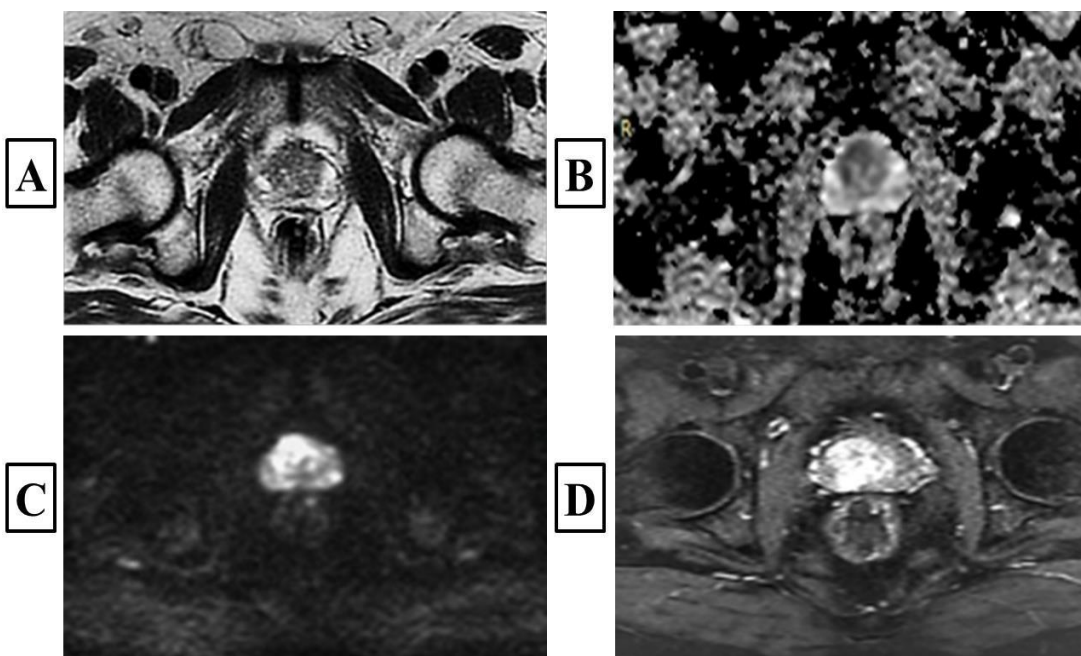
shows prostatic adenocarcinoma with Gleason score 4 + 3 in a 68-year-old male patient with serum PSA = 60 ng/ml. (A) Axial T2WI shows circumscribed homogeneous moderate hypointense mass > 1.5 cm seen involving the transitional zone. (B) Axial ADC shows focal markedly hypointense mass >1.5 cm. (C) Axial high b value DWI shows focal markedly hyperintense mass >1.5 cm (the final PI-RADS score on basis bpMRI was score 5). (D) Axial DCE shows +ve contrast enhancement. The final PI-RADS score based on mpMRI was score 5, DCE did not aid in the diagnosis of this case, and it was already diagnosed by bpMRI.
